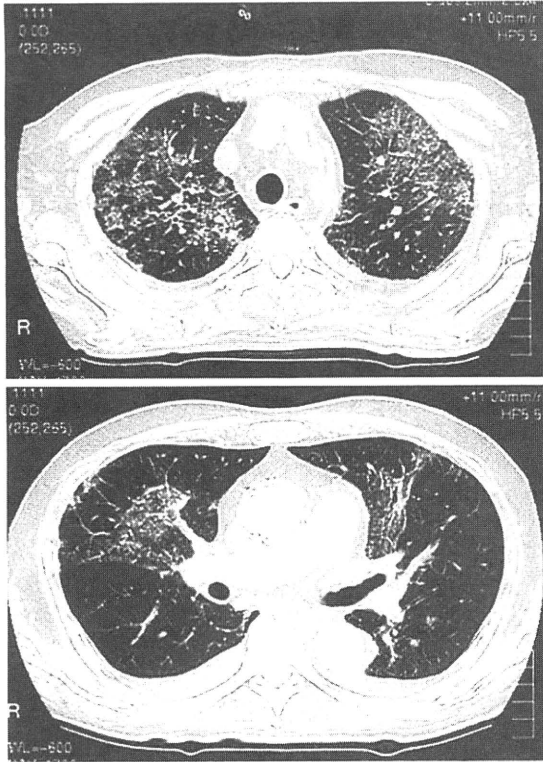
A chest CT scan on day 442 after allo-HSCT. The chest CT shows multifocal, segmental, ground-glass opacities in the upper and mid-lung fields bilaterally, with bilateral pleural effusions.
